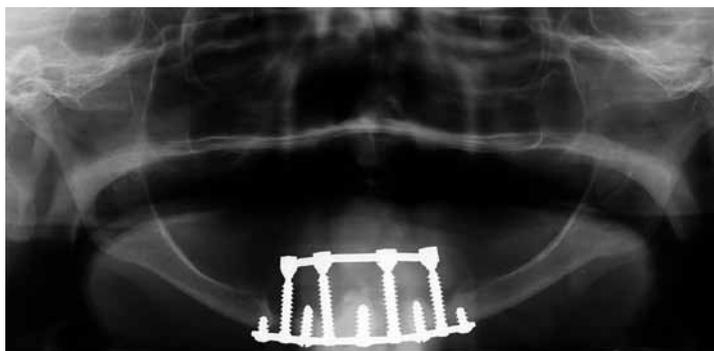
Orthopantomogram. Severe bone loss was observed.
